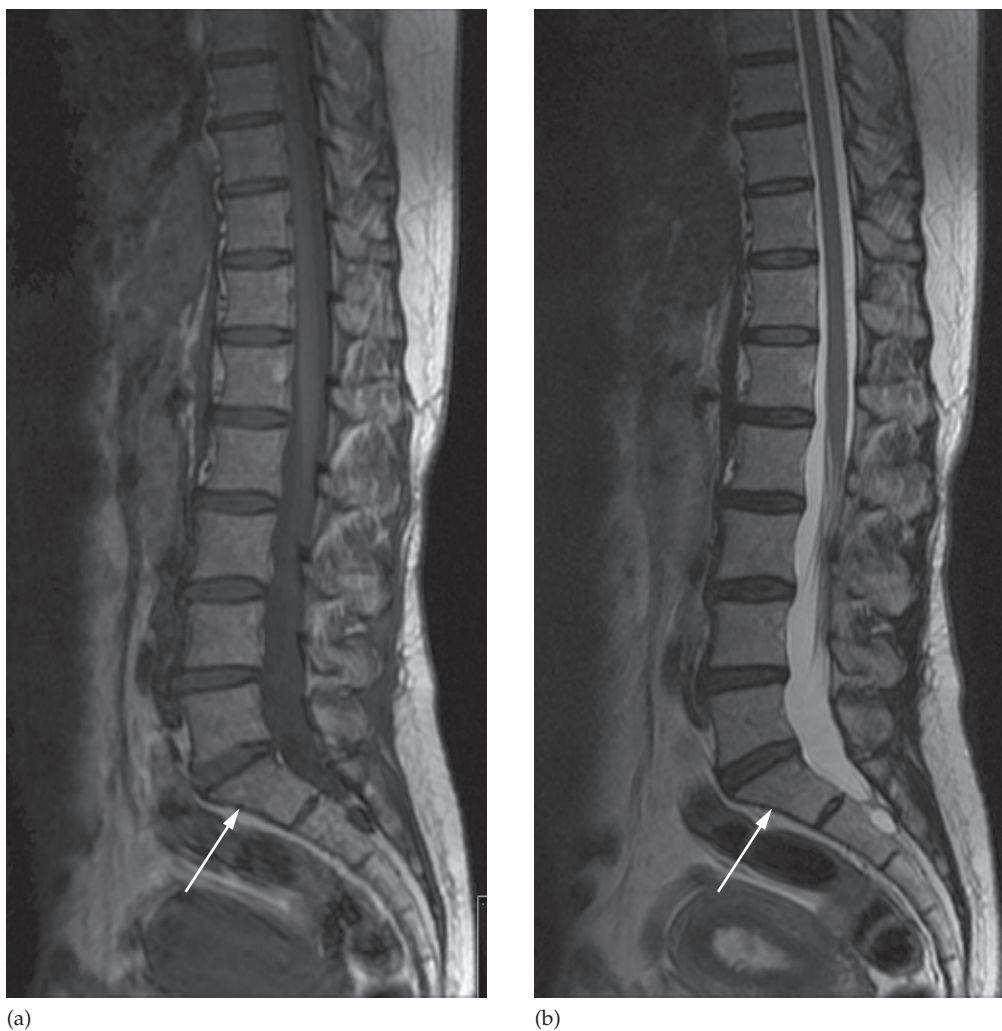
MRI of a sagittal section of lumbar spine. (a) On this T1 sequence, the spinal cord is grey, cerebrospinal fluid (CSF) is nearly black and subcutaneous fat is white. (b) T2-weighted sequence. Here the CSF is white. Cortical bone (arrows) returns no signal and appears as a black line on both sequences. The fat in the bone marrow produces a signal that enables the vertebrae to be visualized.
